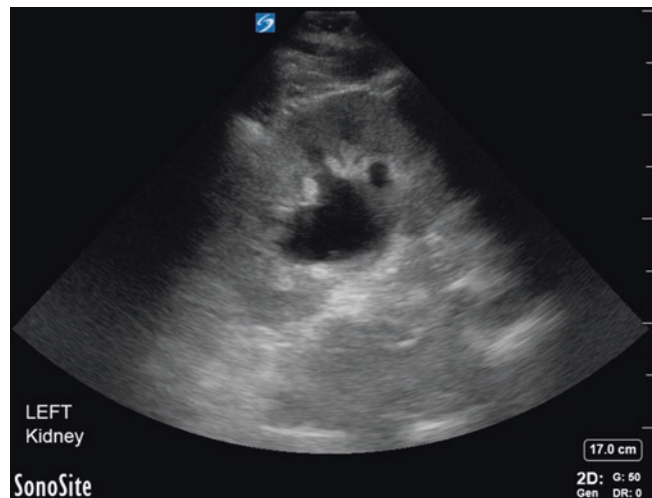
Ultrasound findings
